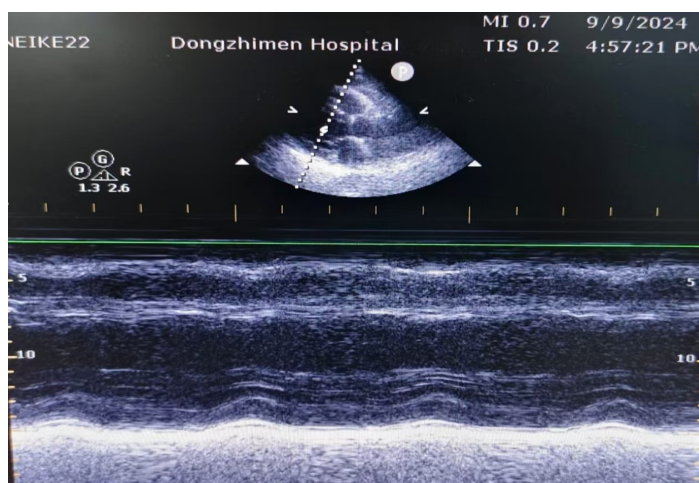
Echocardiogram after treatment with traditional Chinese medicine
